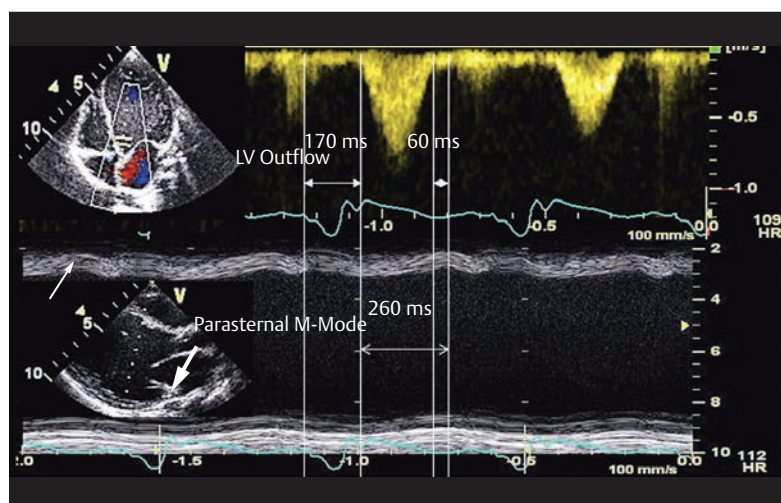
Time course of left ventricular ejection in a case of pronounced dyssynchrony. Temporal compiled image of the pulse Doppler acquisition from the LVOT (top) and the parasternal M-mode depiction (bottom). Left ventricular ejection is delayed by pronounced dyssynchrony (left ventricular pre-ejection period of 170 ms) and begins once the septum contracts (thin arrow). The maximum contraction of the free wall of the left ventricle is delayed by 260 ms compared to the septum (known as septal to posterior wall motion delay; thick arrow) and first occurs 60 ms after closure of the aortic valve. Thus, a significant portion of left ventricular contraction no longer contributes to ejection.
